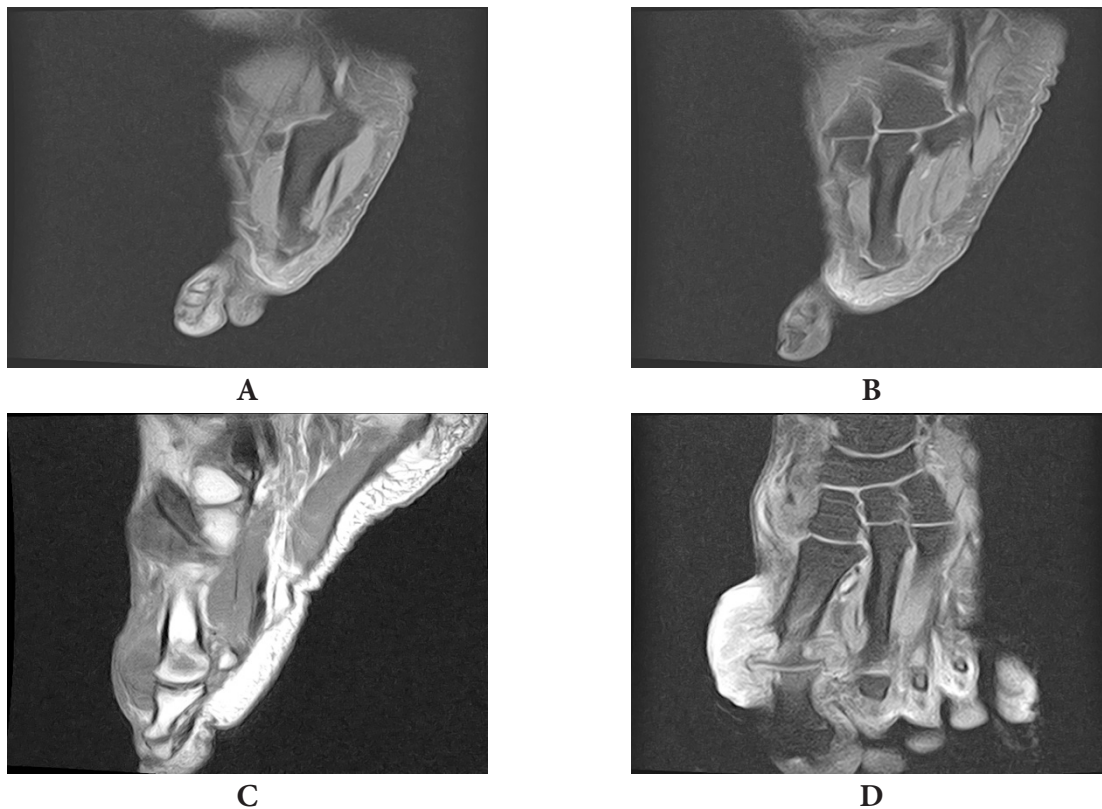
Magnetic resonance imaging (MRI) of the left foot. (A) Coronal T1-weighted fat-suppressed image showing multiple periarticular tophaceous deposits (arrows) around the first MTP joint with slightly prolonged T1 signal. (B) Sagittal T1-weighted fat-suppressed image demonstrating tophaceous deposits along the dorsal aspect of the first MTP joint. (C) Axial T2-weighted image revealing minimal joint effusion (arrowhead). (D) Coronal T2-weighted image showing preserved joint alignment with minimal periarticular soft tissue changes. Findings are consistent with gouty arthritis and multiple tophi.
